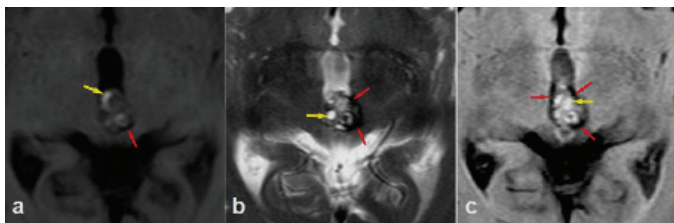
Axial T1-weighted (a), T2-weighted (b) and FLAIR (c) images showing a mass with intralesional bright hyperintensities (yellow arrows) and a perilesional hypointense rim (red arrows)
